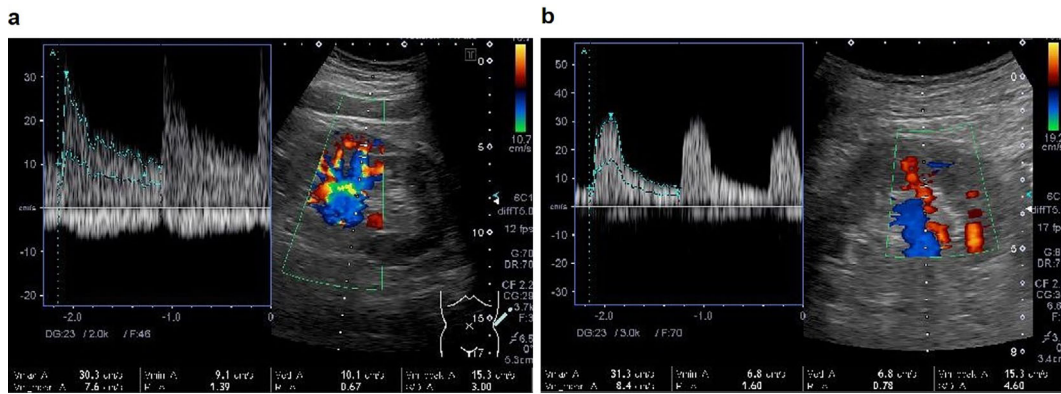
Color Doppler imaging of the RRI. RRI: renal resistive index
